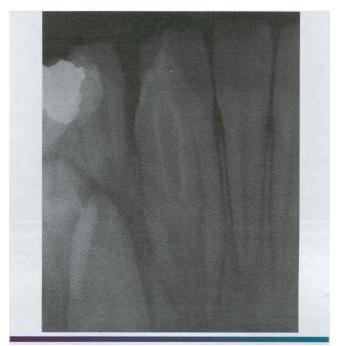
• Coronal dens invaginatus, type II. Radiograph of the mandibular lateral incisor depicted in Figure 2-70. Note the radiopaque and enamel-lined invagination extending below the level of the cementoe namel junction.
